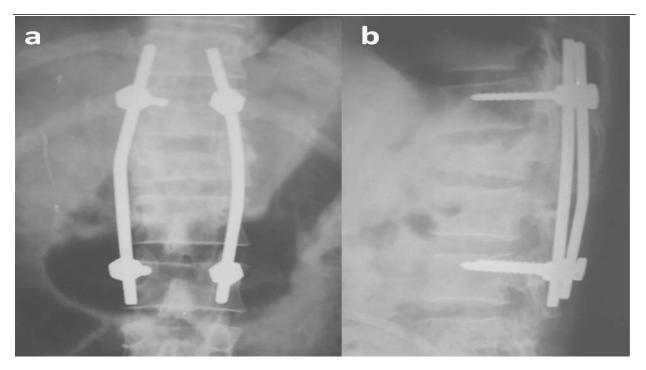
Anteroposterior and lateral radiograph of thoracolumbar spine of same patient after 6 months follow up showing well maintained height of L1 vetebra and curvature of spine along with stable pedicle and rod construct.
